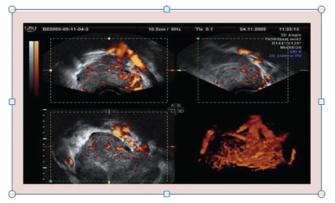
3D reconstruction of the vascular tree from an ovarian tumor depicted by power Doppler ultrasound.
